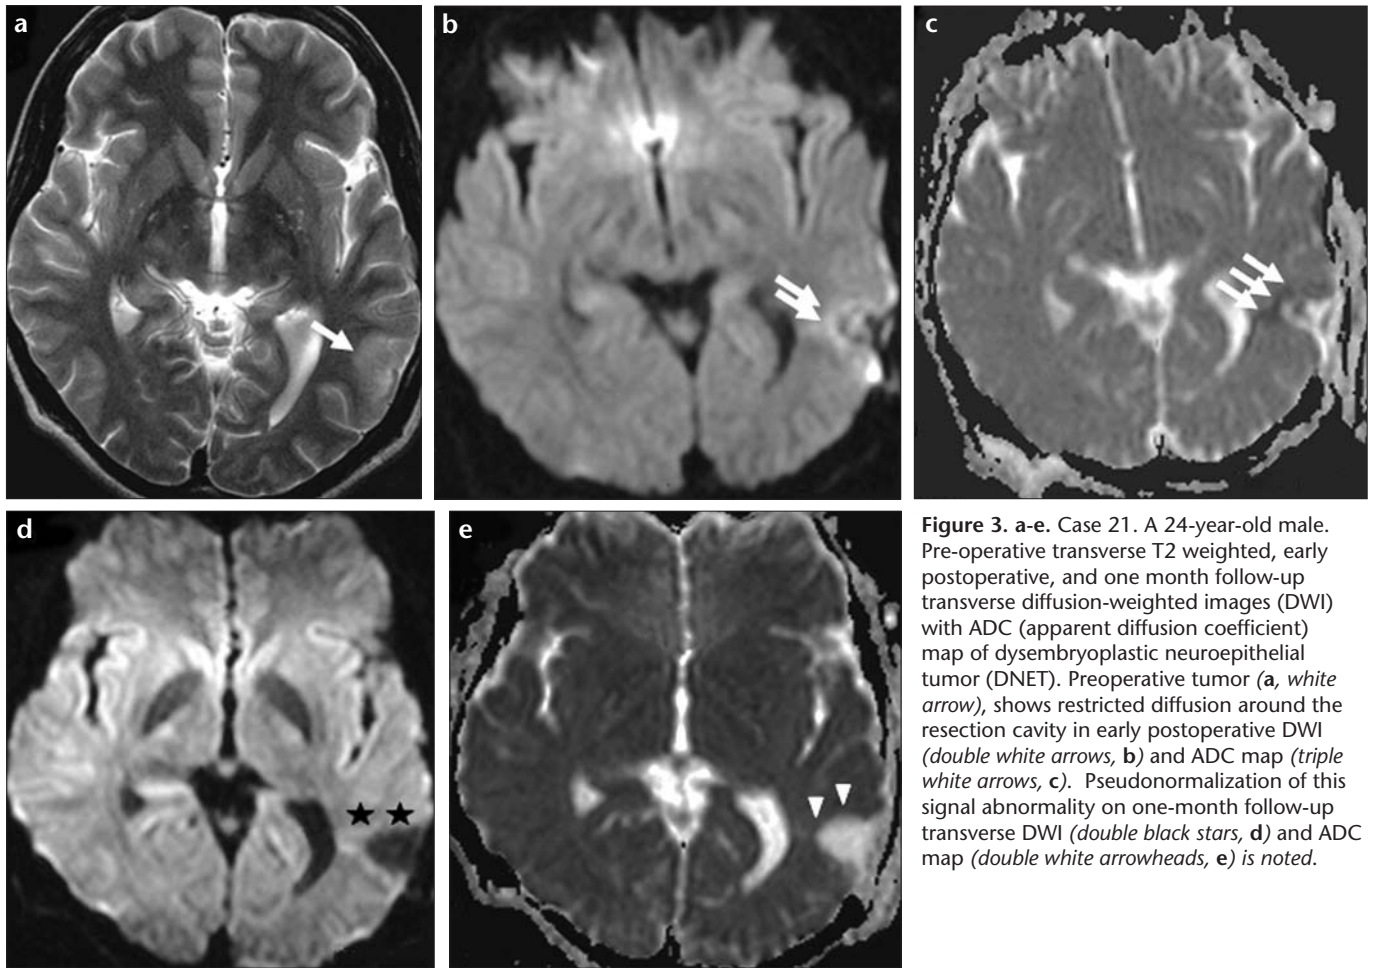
a-e. Case 21. A 24-year-old male. Pre-operative transverse T2 weighted, early postoperative, and one month follow-up transverse diffusion-weighted images (DWI) with ADC (apparent diffusion coefficient) map of dysembryoplastic neuroepithelial tumor (DNET). Preoperative tumor (a, white arrow), shows restricted diffusion around the resection cavity in early postoperative DWI (double white arrows, b) and ADC map (triple white arrows, c). Pseudonormalization of this signal abnormality on one-month follow-up transverse DWI (double black stars, d) and ADC map (double white arrowheads, e) is noted.
